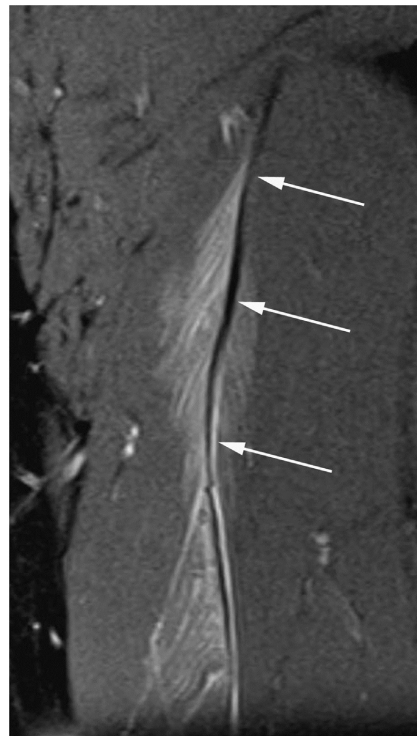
When signal changes (oedema or tears) were centered next to the proximal or distal myotendinous junction, the myotendinous junction was used for grading. This coronal PDw-FS MRI shows muscle oedema surrounding the proximal myotendinous junction of the long head of biceps femoris. Note that the adjacent tendon exhibits normal signal and morphology (arrows). For the Chan classification, we considered this injury as grade 1 in terms of severity, located to the proximal myotendinous junction (anatomical location 1) regarding its location. Using the British Athletics muscle injury classification, this injury was considered as grade 2b. Using the modified Peetrans grading system, both injuries were considered as grade 1.
